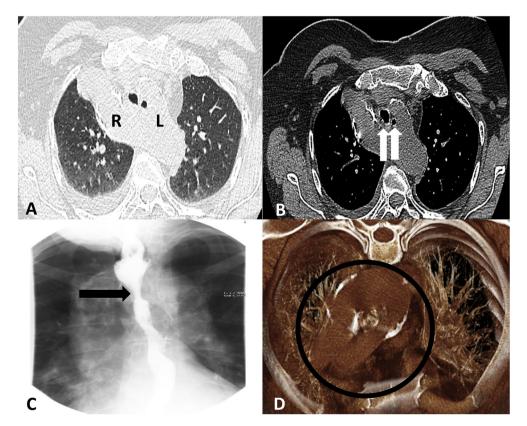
Radiographic images demonstrating DAA. The right (R) and left (L) arch are seen (A), along with the trachea and esophagus (B, arrows). Esophagram (C) demonstrates obstruction and reconstructed images (D, circle) highlight the DAA. Her aortic calcification is also readily evident.
